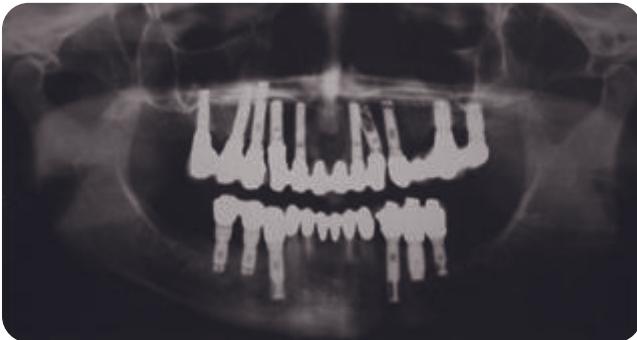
Posttreatment panoramic radiograph. Lower anteriors still maintained as of 8 years posttreatment completion of upper anterior.
